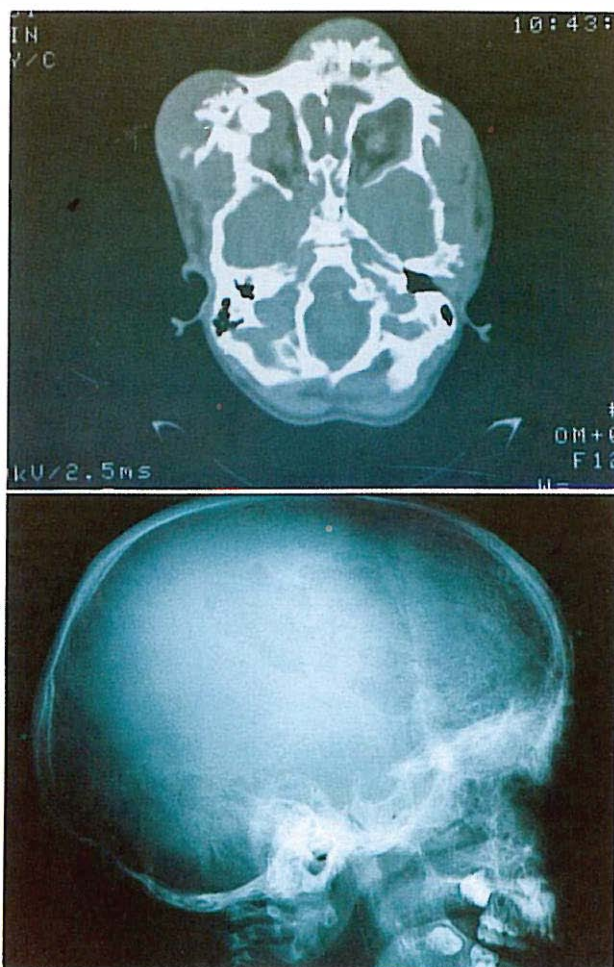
Skull x-rays and C.T. scans show sunburst appearance of the fronto-orbital bones.
